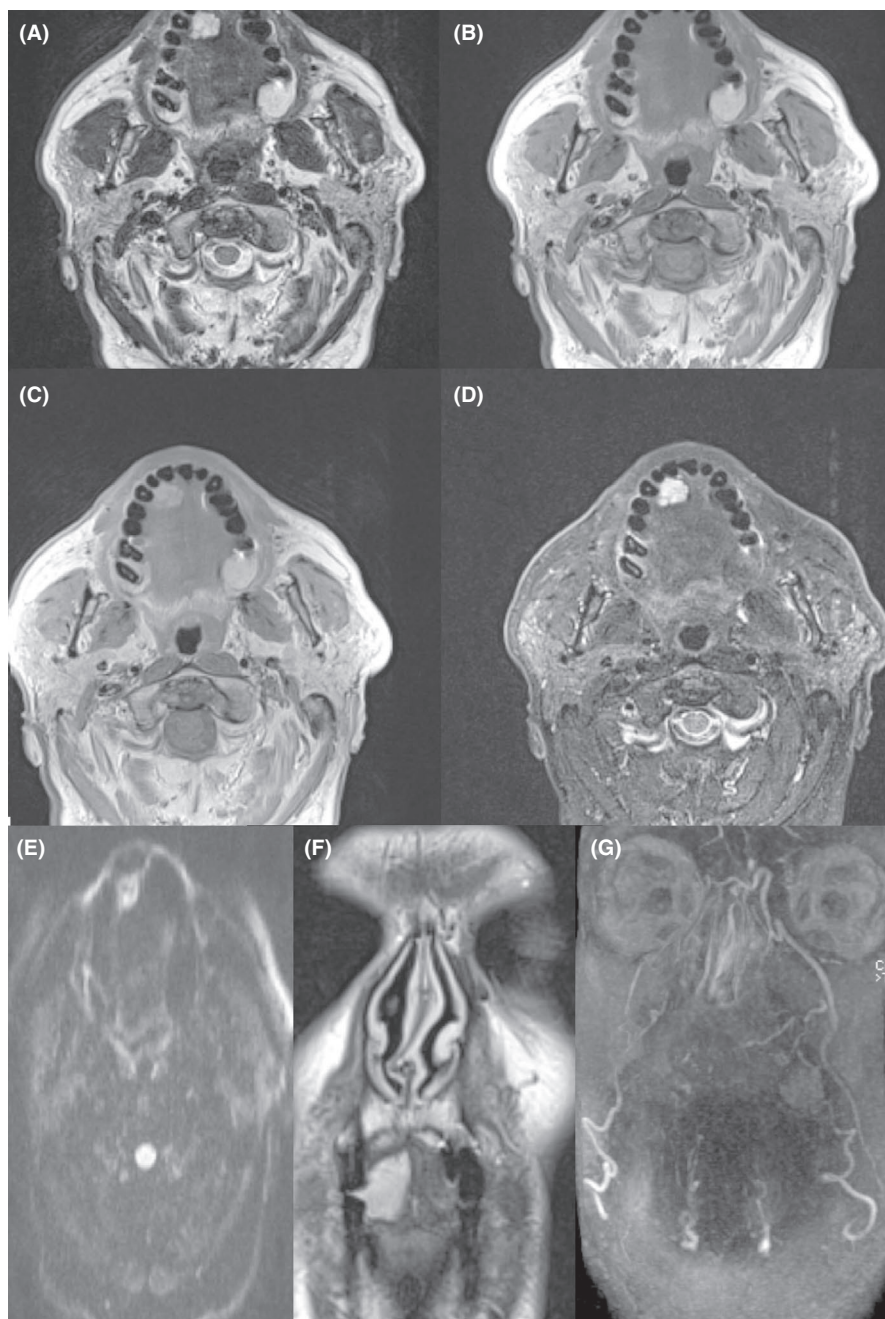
Axial T2-weighted MRI image shows a hyperintense lesion (A) that is isointense in T1-weighted without contrast (B) and hyperintense and well defined with clear and lobulated margins after contrast injection (C). With turbo inversion recovery magnitude sequences, thin internal septa are visible (D). Axial magnetic resonance imaging scan shows no signal restriction in diffusion-weighted imaging (E). The T2-weighted coronal scan shows a highly hyperintense lesion (F). Maximum intensity projection angiographic study shows significant "feeders" detectable in the anterior lingual region, with a small vascular agglomerate (G)
